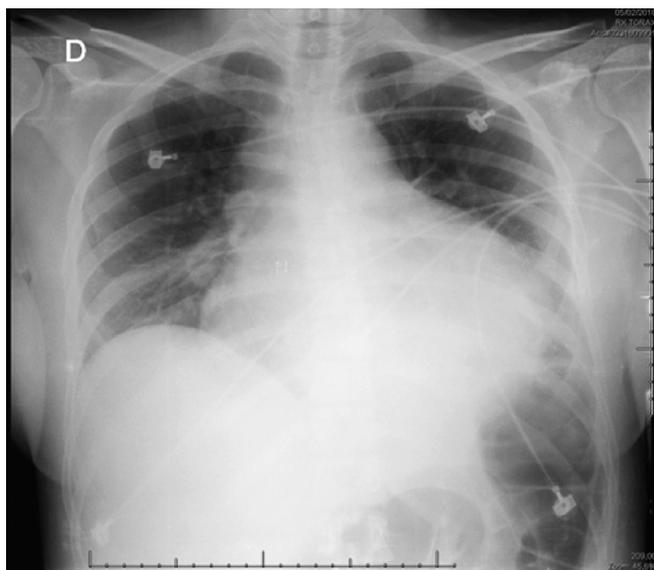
Anteroposterior chest X-ray showing increased cardiac area.
